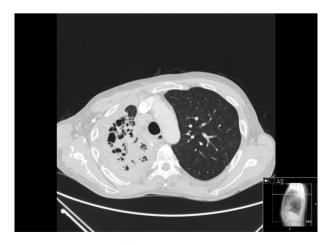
Computed tomography of the chest showed decreased right lung volume and associated pleural effusion.
